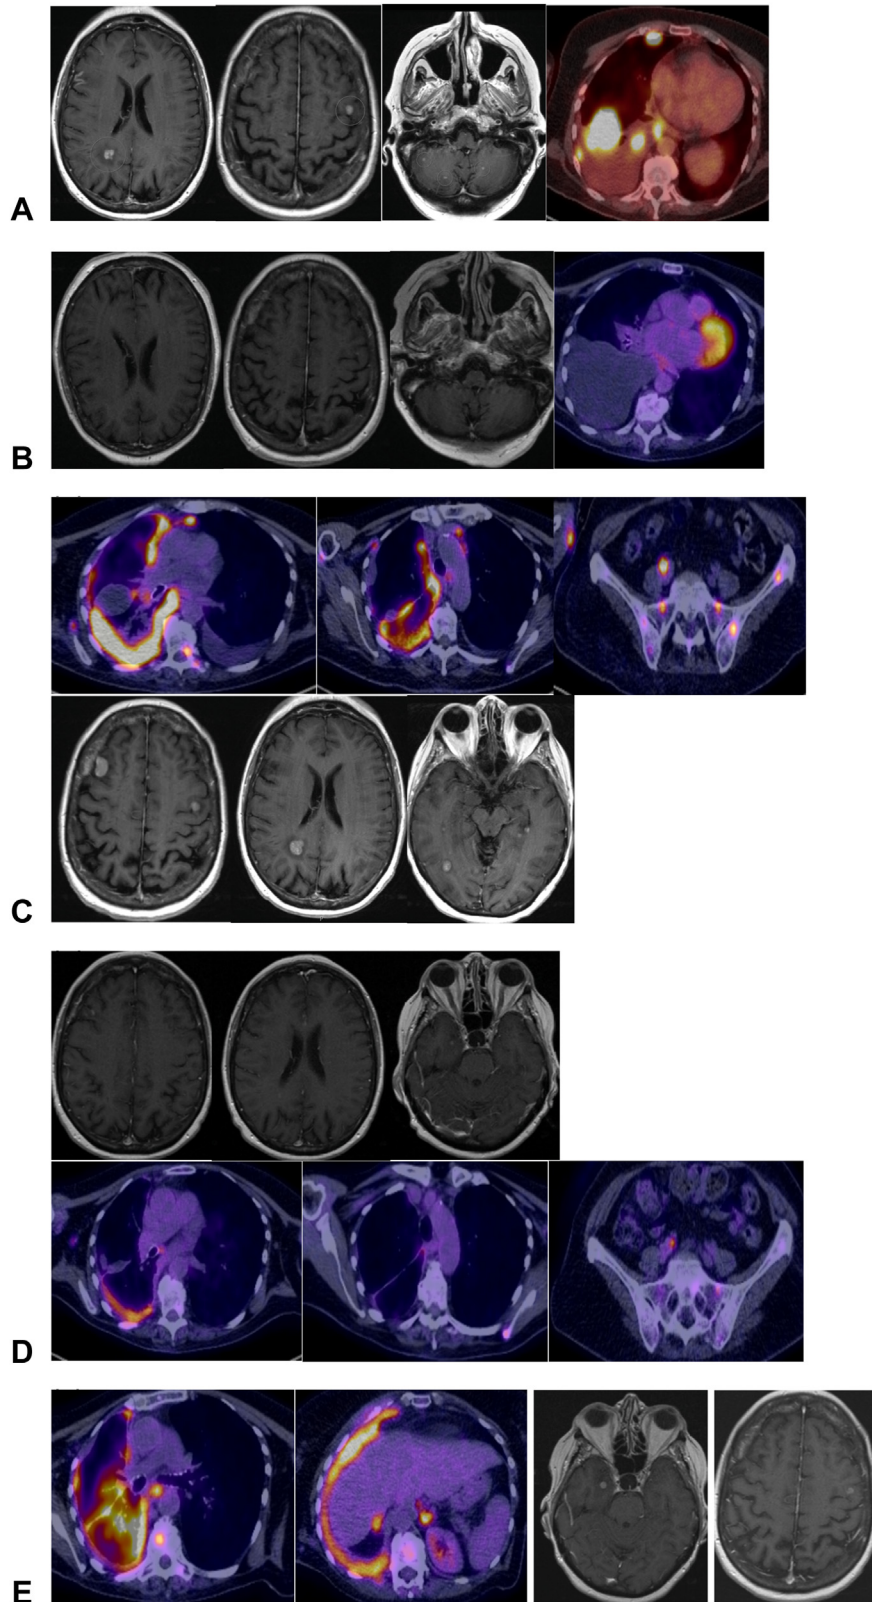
Radiology images on therapy. (A) CT, FDG PET-CT, and MRI brain images at diagnosis. (B) Response imaging after two months on crizotinib, revealing a good response. (C) Imaging at progression on crizotinib, coinciding with emergence of a *ROS1* G2101A variant. (D) Imaging revealing a good extracranial and intracranial response after 1 month of lorlatinib treatment. (E) Imaging revealing extracranial progression and intracranial oligoprogression at two sites, after 2 months of lorlatinib treatment. NGS result at this point revealed loss of G2101A and emergence of *ROS1* G2032R and L2086F. CT, computed tomography; FDG PET-CT, 18F-fluorodeoxyglucose positron emission tomography-computed tomography; MRI, magnetic resonance imaging.
